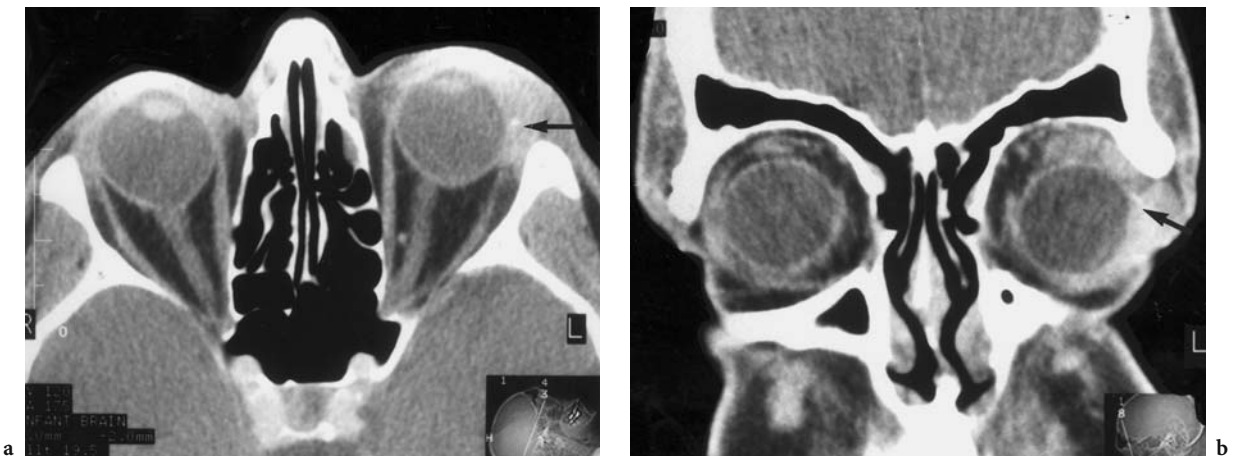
A 66-year-old man with progressive protrusion and undefined pressure of the left eye. Diagnosis: amyloid tumor of the lacrimal gland. CT: a Axial view showing moderate enlargement of the lacrimal gland with a small calcification (arrow). b Coronal view identifying encasement of the superior circumference of the globe
